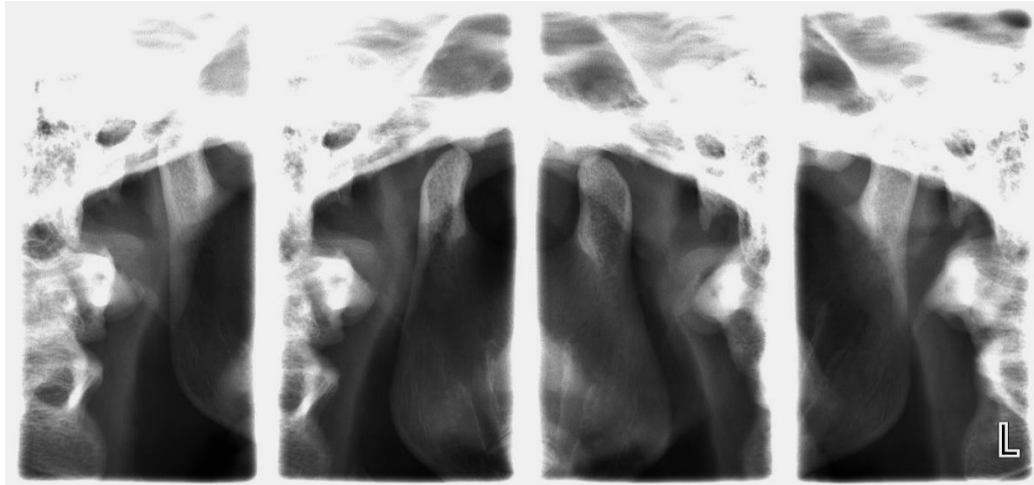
Radiography of the TMJ
